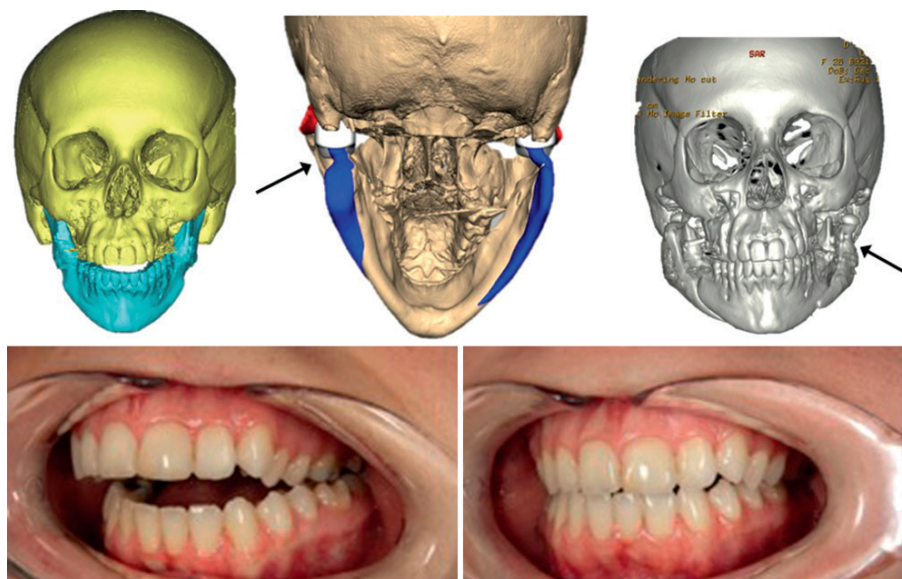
Case # 4. (a) Surface tessellation language render before planning demonstrating the anterior open bite. (b) Surface tessellation language render after planning for bilateral extended temporomandibular joint replacement and mandibular repositioning. The arrow indicates the concavity in the subcondylar area secondary to postoperative maintenance of the yaw position of the mandible and the attempt to symmetrize the mandibular angle area by augmentation. (c) Postimplantation CT scan, frontal view. The arrow indicates the mid-cheek concavity. (d) Left — profile view of the preoperative occlusion. (e) Left— profile view of the post-eTMJR occlusion
